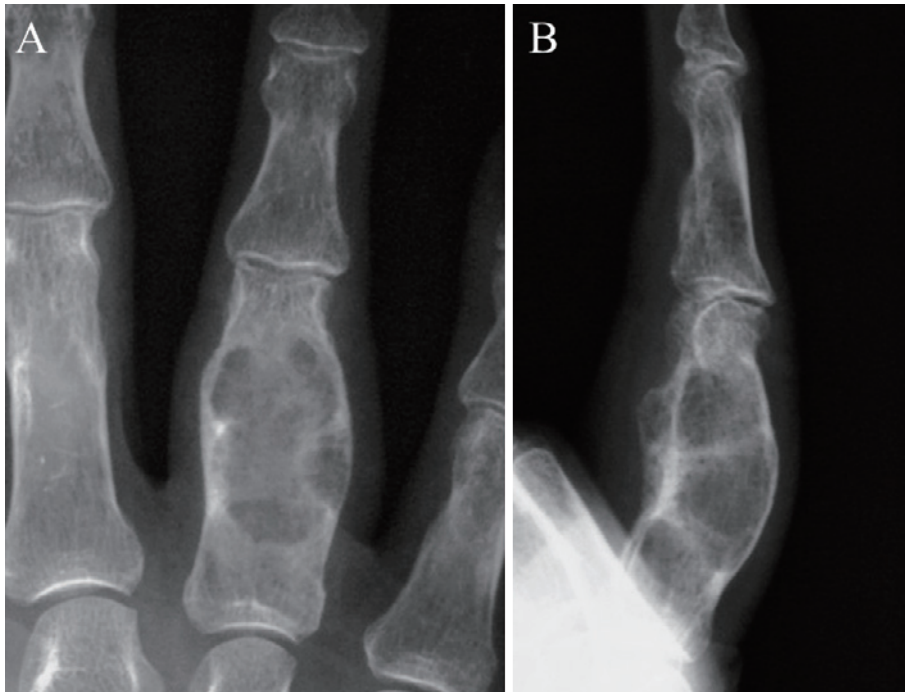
Radiographs of the patient's right ring finger, showing a multilobate radiolucent region without calcification on his second visit to our hospital.
